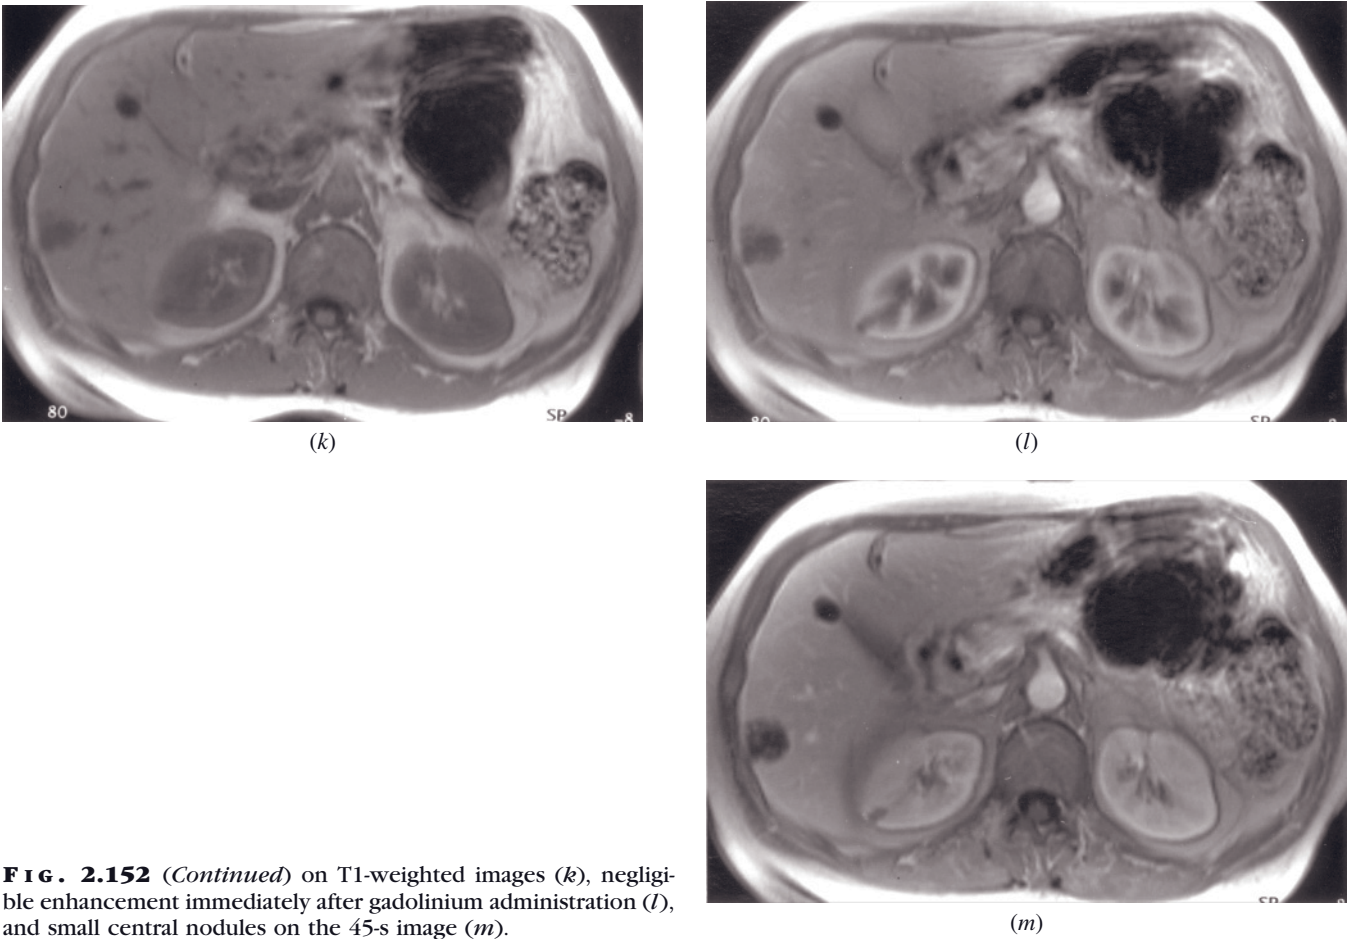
(Continued) on T1-weighted images (*k*), negligible enhancement immediately after gadolinium administration (*l*), and small central nodules on the 45-s image (*m*).
